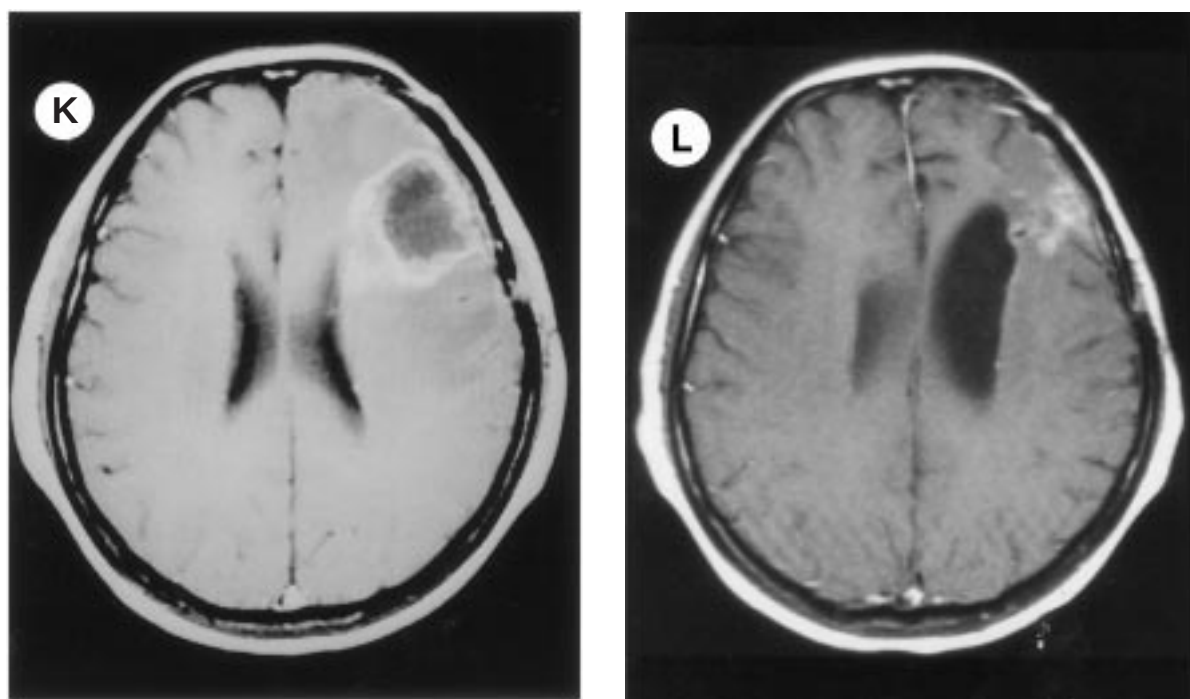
Gadolinium enhanced MR imaging studies just prior to the first TIL immunotherapy infusion and follow-up studies. All pre-immunotherapy MR imaging studies were performed 6 weeks following surgery, at which time TILs had been expanded *in vitro* and were available for infusion. A and B: Case 1, demonstrating partial response to therapy at 48 months. C and D: Case 2, demonstrating a partial response to therapy at 47 months. The centrally enhancing lesion is a previously diagnosed meningioma. E and F: Case 3, demonstrating a complete response to therapy at 45 months. G and H: Case 4, demonstrating progressive disease at 6 months. I and J: Case 5, patient with a partial response to treatment followed by recurrence at 6 months. K and L: Case 6, demonstrating a partial response to therapy at 6 months.
